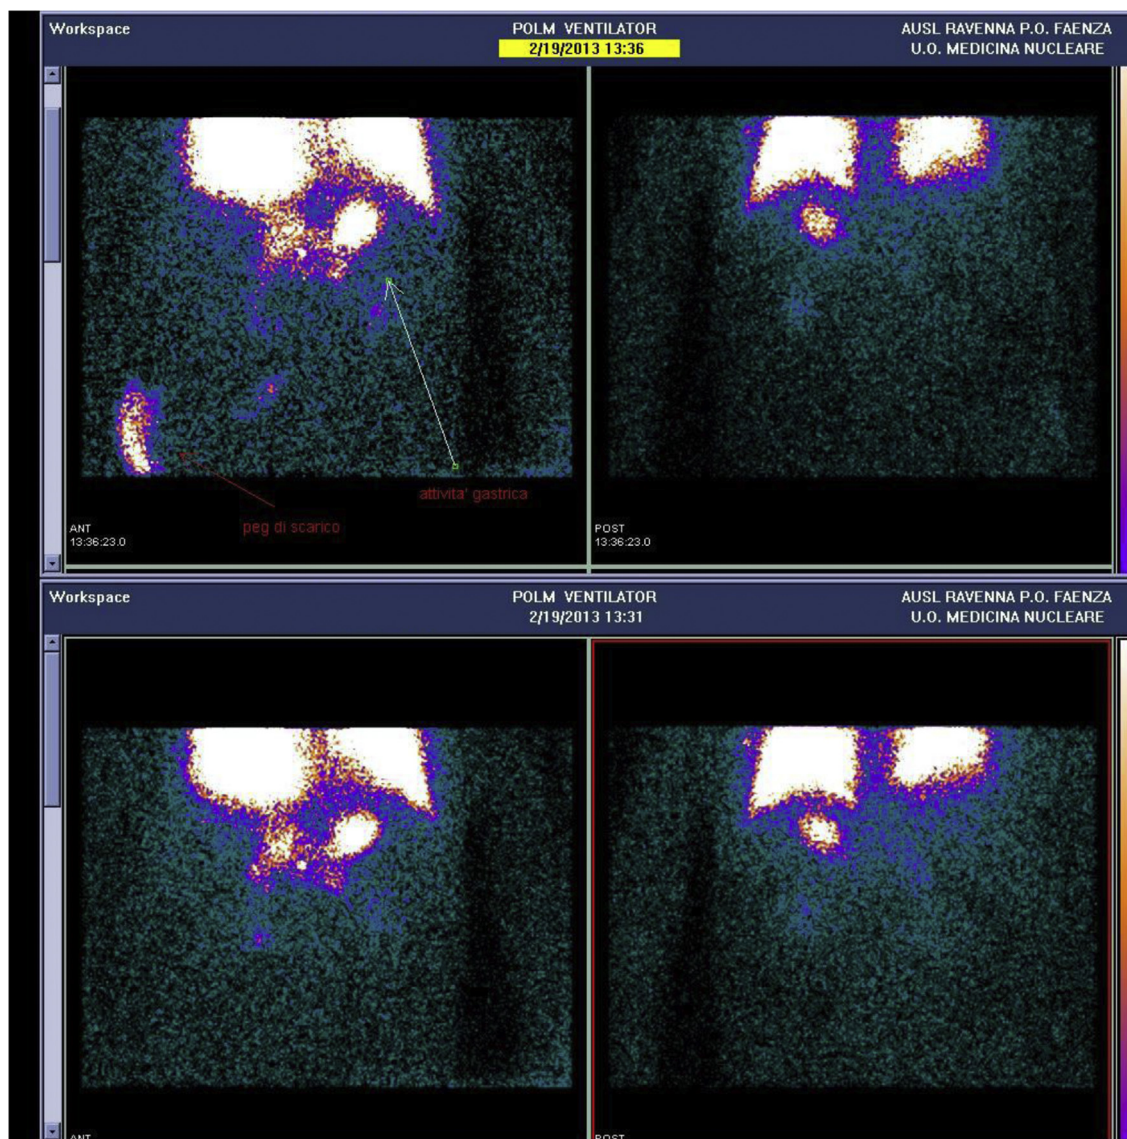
SPECT/CT demonstrated a possible passage of radiolabelled air from right lung to the stomach.
